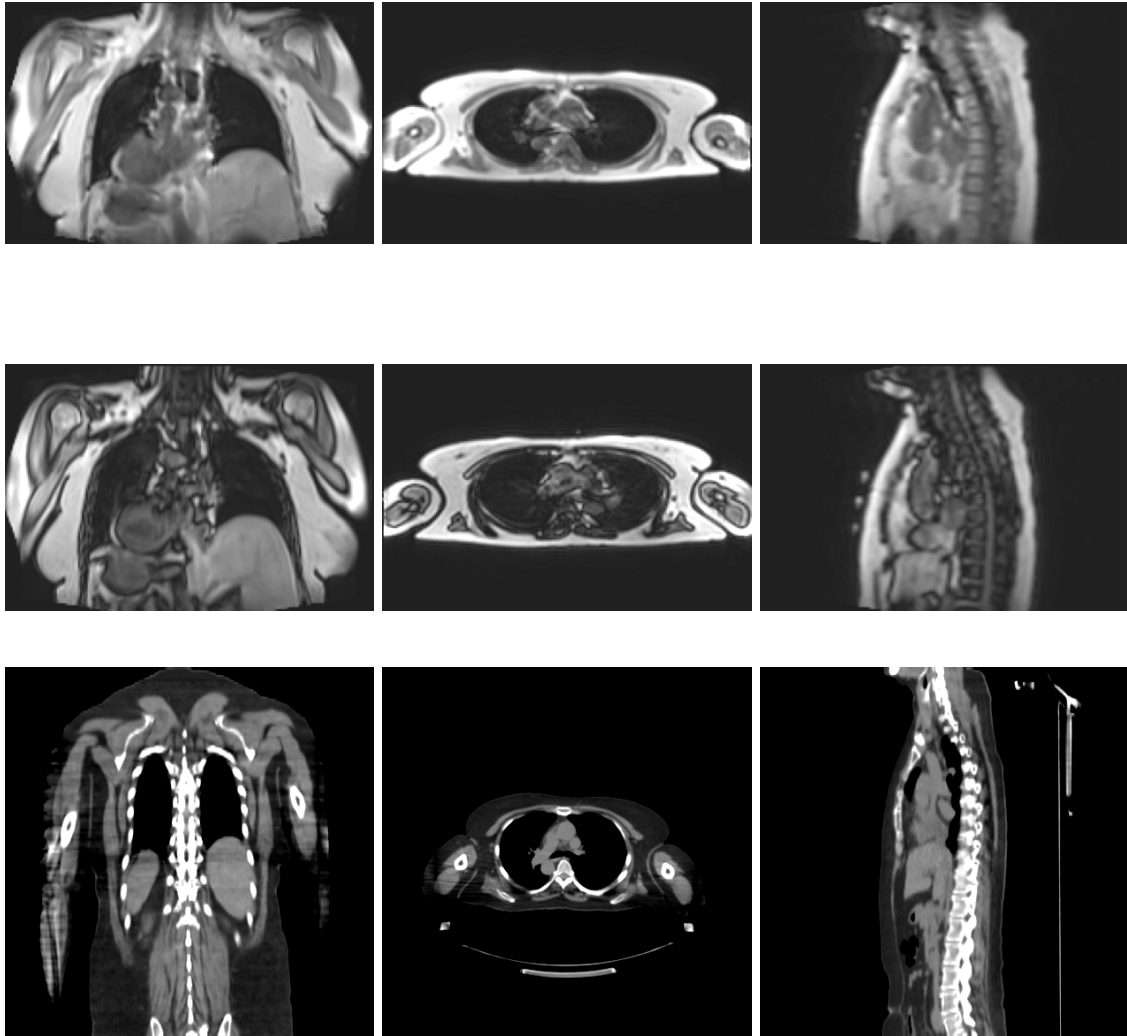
Original MR and CT images before preprocessing. Top row: In-phase MR images showing coronal (left), axial (middle), and sagittal (right) views. Middle row: Out-of-phase MR images in corresponding views. Bottom row: Corresponding CT views.
